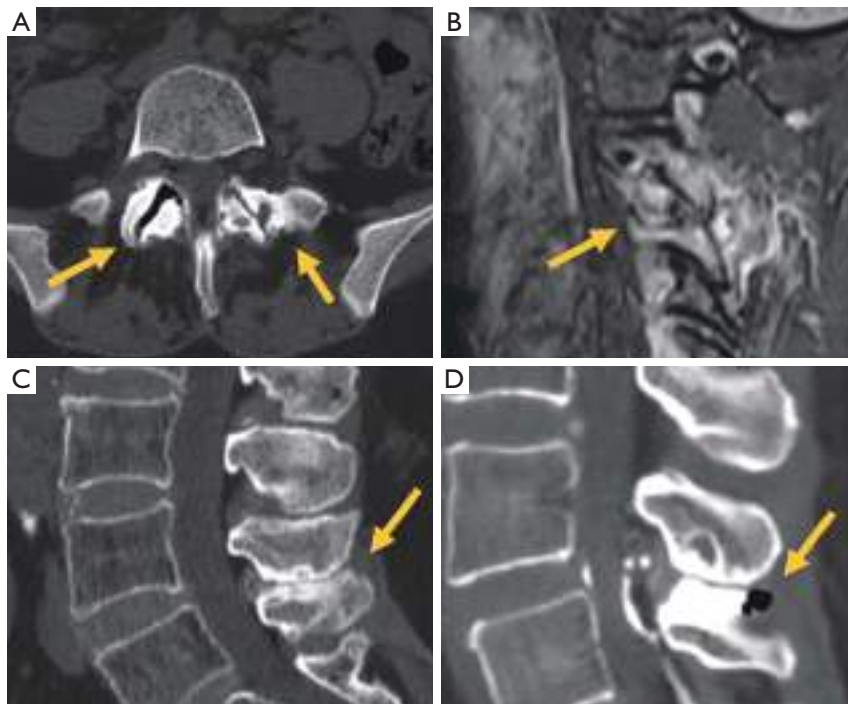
Osteoarthritis of the posterior elements. (A) Axial CT of facet joint osteoarthritis (arrows). (B) Sagittal STIR showing edema in cervical facet joint osteoarthritis (arrow). (C) Sagittal CT showing Bastrup's disease (arrow). (D) Interspinous bursitis (arrow) demonstrated during injection with dye and steroids of the facets joint. CT, computed tomography; STIR, short tau inversion recovery.
